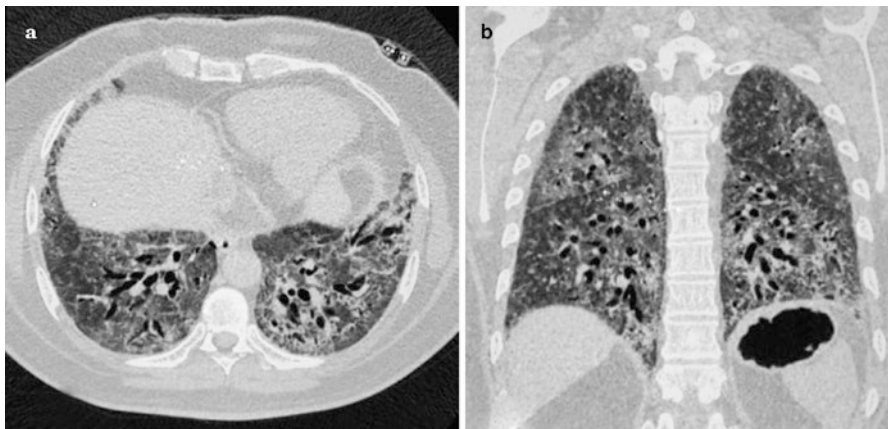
A 57-year-old male, known hypertensive, diabetic and asthmatic, presented with fever, productive cough, and chest pain. CT scan chest (a, axial view and b, coronal view) shows bilateral interlobular septal thickening with ground glass opacities and traction bronchiectasis
